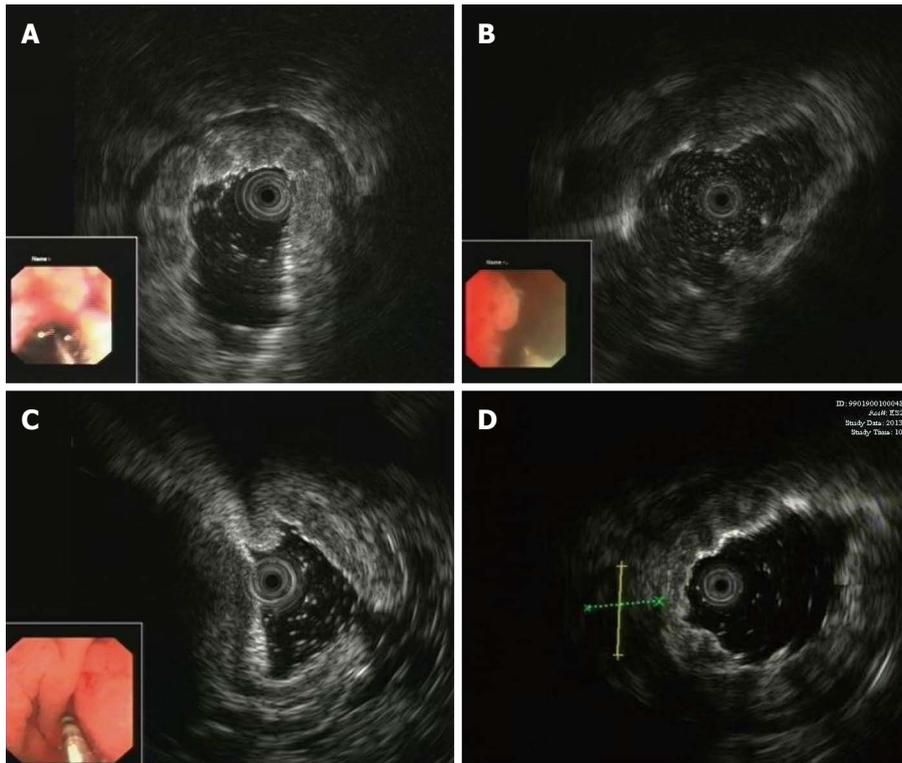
Endoscopic ultrasound characteristics of gastric infiltrating tumors. A: Invaded muscularis propria and the first three blurred sonographic layers; B: Invaded serosal layer; C: Ascites around gastric wall; D: Perigastric lymph node.
